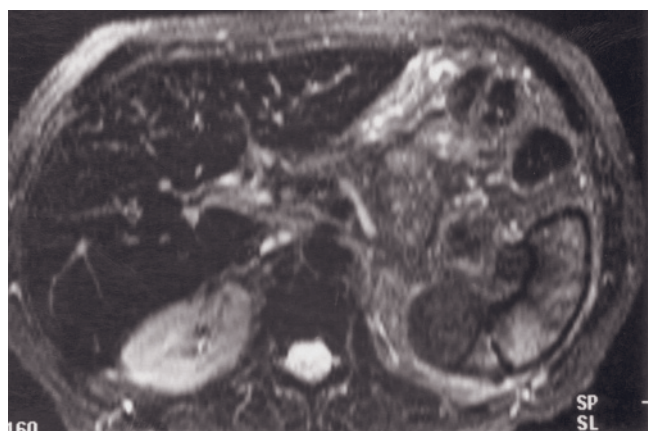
Extensive posterior splenic infarct. T1-weighted SGE (a), coronal T2-weighted single-shot echo-train spin-echo (b), immediate (c) and 45-s (d) postgadolinium T1-weighted SGE, and 90-s postgadolinium T1-weighted fat-suppressed SGE (e) images. The splenic infarcts appear heterogeneous and mildly high signal on T1-weighted (arrow, a) and heterogeneous and moderately high signal on T2-weighted (arrow, b) images. On the immediate (c), 45-s (d), and 90-s (e) postgadolinium images there is
